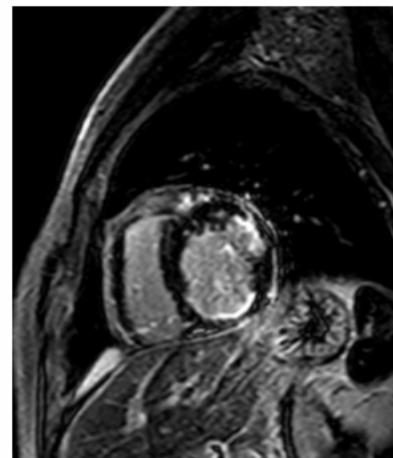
Cardiac MRI late gadolinium post contrast images demonstrate subendocardial (curved arrow) and transmural (straight arrow) infarcts in LV myocardium.
